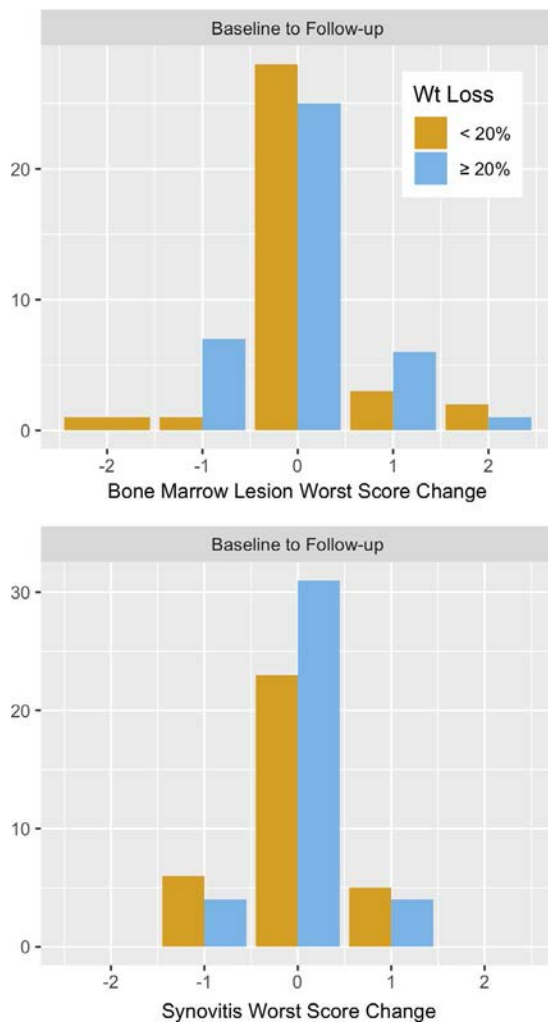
Longitudinal changes in bone marrow lesion and synovitis worst scores, measured semiquantitatively by magnetic resonance imaging, stratified by weight (Wt) loss from baseline to 1-year follow-up.
